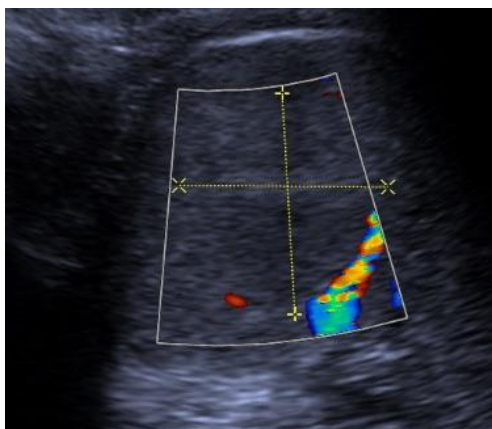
shows the doppler examination of the seventeen years old boy with SANT lesion. There is not any color spectrum representing vascularization in the lesion. The vascular structures of the intraparenchymal in the spleen was slightly depressed to laterally.
